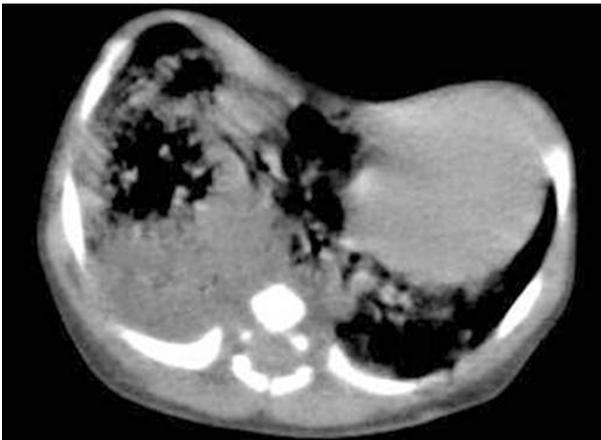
First computed tomography scan; multiple small cystic filled with air in the middle lobe of the lung and heart was pushed to left of chest
